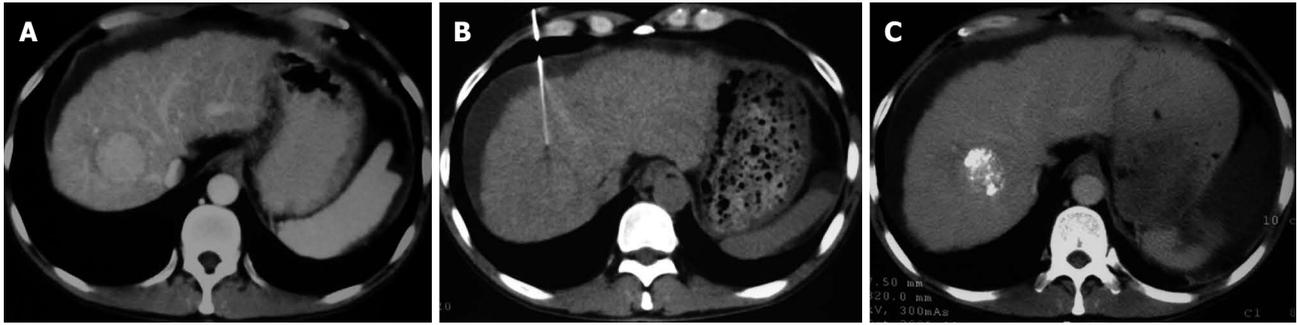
Contrast computed tomography showing a nodule (3.5 cm in diameter) in the right upper liver lobe manifested as homogenous enhancement (A); computed tomography scan (b) demonstrating the course of fine needle biopsy under computed tomography guidance with the diagnosis of hepatocellular carcinoma confirmed (B); computed tomography follow-up (c) revealing lipiodol deposit in the mass and spleen infarction after spleen embolization (C) in a 52-year-old man with multiple hepatic nodules, liver cirrhosis, splenomegaly and elevated alpha-fetoprotein.
